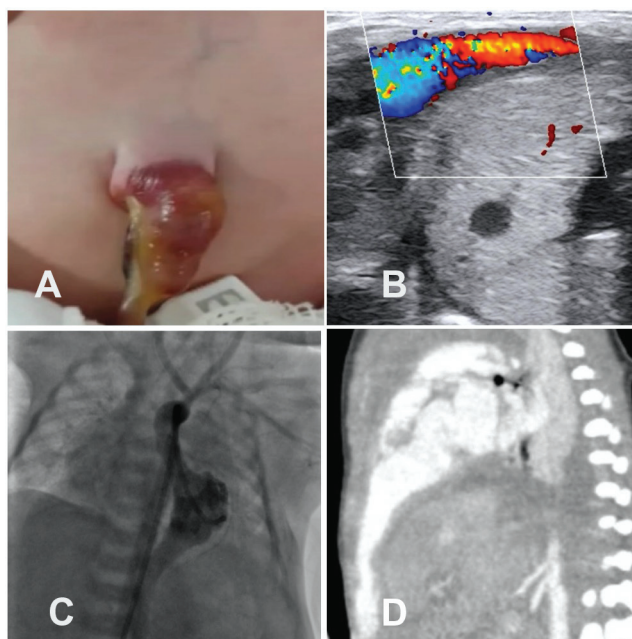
The tip of the left ventricular diverticulum presented as a pulsatile umbilicus (A). Color Doppler echocardiography of the patient shows the diverticulum immediately under the skin (B). Angiography of the left ventricle from the femoral artery reveals the connection between the diverticulum and the umbilicus (C). In this sagittal view of the chest and abdominal CT angiography, the extension of the diverticulum is better delineated (D).
